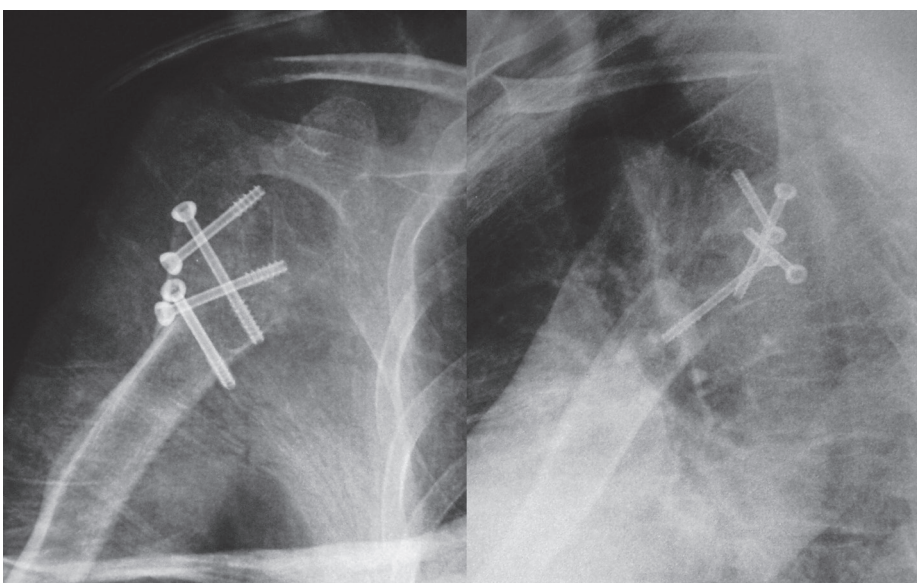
AP and lateral position radiographs taken 3 months after the operation, showing the bridging bone between the fragments, which both indicate that bone union has been achieved
